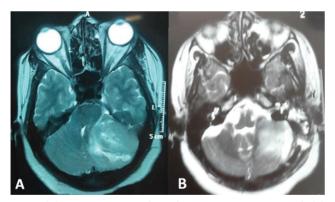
(A) Preoperative MRI brain hyperintense on T2W axial. (B) Postoperative MRI brain showing complete excision of the tumor.
